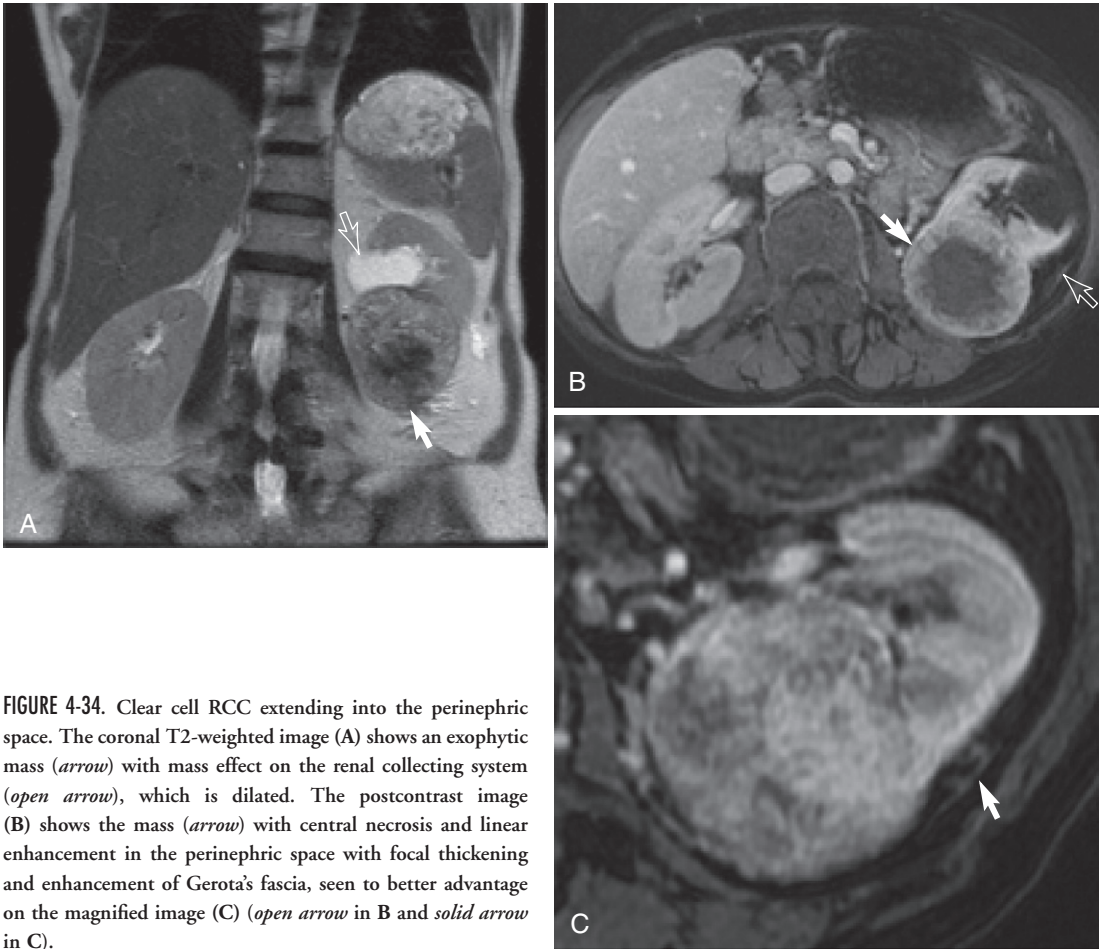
Clear cell RCC extending into the perinephric space. The coronal T2-weighted image (A) shows an exophytic mass (*arrow*) with mass effect on the renal collecting system (*open arrow*), which is dilated. The postcontrast image (B) shows the mass (*arrow*) with central necrosis and linear enhancement in the perinephric space with focal thickening and enhancement of Gerota's fascia, seen to better advantage on the magnified image (C) (*open arrow* in B and *solid arrow* in C).
